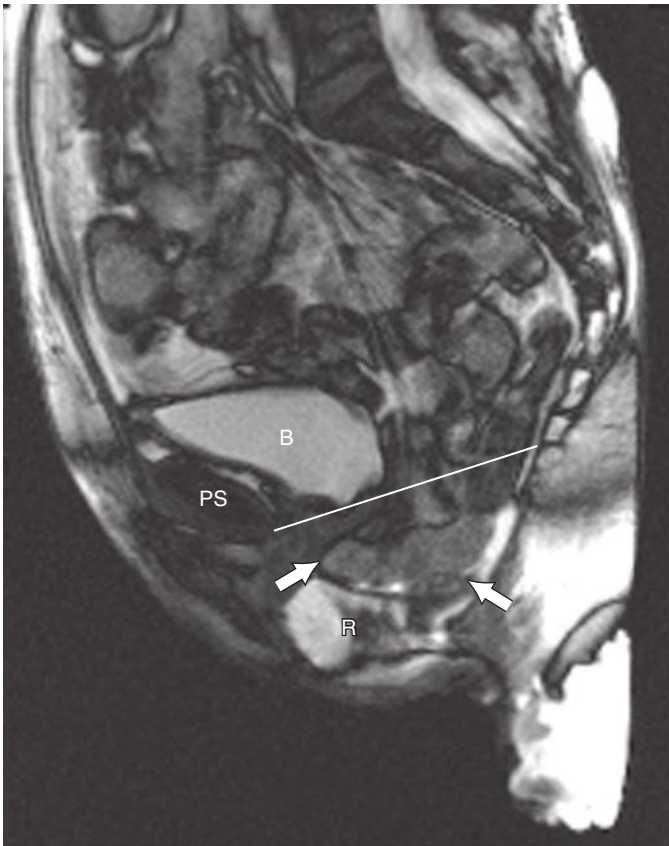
Enterocele on strain magnetic resonance image. Sagittal T2-weighted image of the pelvis during strain shows the protrusion of multiple loops of bowel below the pubococcygeal line (PCL) (*white line*) between the displaced rectum (R) and urinary bladder (B), consistent with enterocele (*arrows*). The vagina is not well seen in this plane. PS, pubic symphysis. (Courtesy Gaurav Khatri MD, UT Southwestern Medical Center.)
